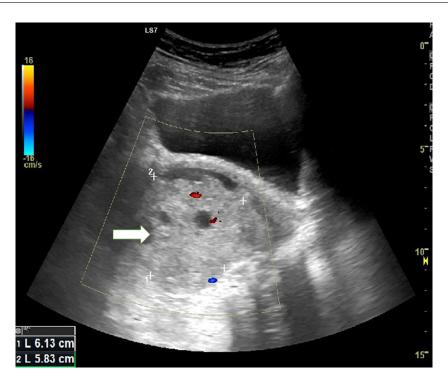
Pelvic ultrasonography shows ill-defined border tumor inside the uterus with a heterogeneous echotexture (arrow).
